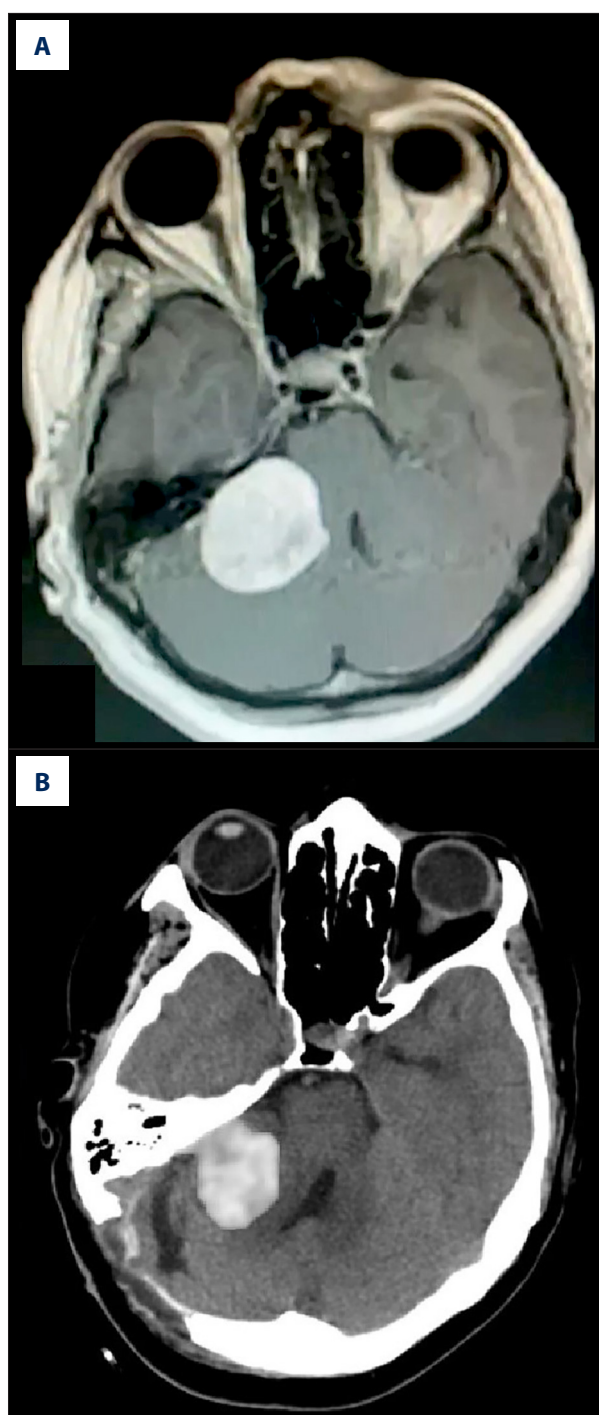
Preoperative and postoperative imaging of a large vestibular schwannoma with hemorrhagic complications. (A) Preoperative cranial MRI showing a large vestibular schwannoma on the right side. (B) Postoperative CT scan revealing hemorrhage within the surgical site. (C) Follow-up CT scan after evacuation of the hemorrhage, demonstrating residual tumor (black arrow) without evidence of further bleeding. MRI – magnetic resonance imaging; CT – computed tomography.
